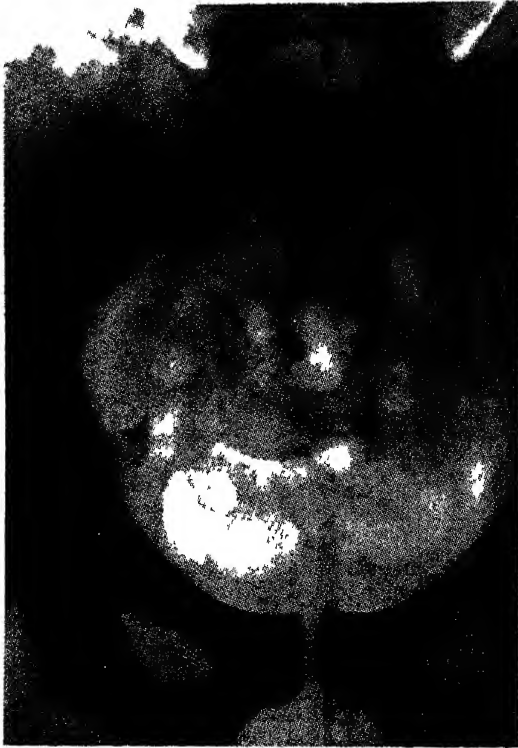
Roentgenogram made in December, 1936. The calcified fecalith can be seen lying in the right lower quadrant. At the time this film was made, there was nothing in the history or physical examination to point to trouble in the appendix. (Shelley Surgery, May, 1938.)
